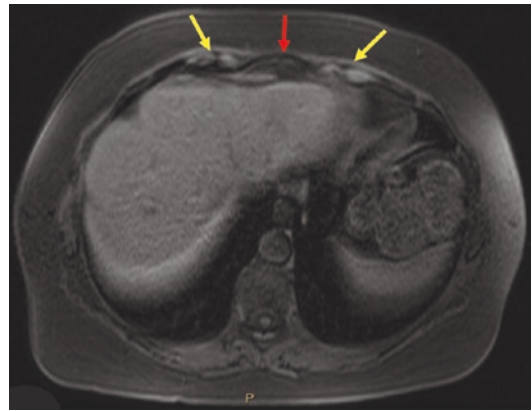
MR image performed in the T1 phase. In this phase, the rectus abdominis muscles (yellow arrows) are bright
